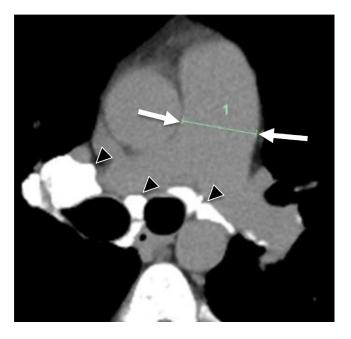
Axial noncontrast CT reveals an enlarged main pulmonary artery measuring 3.4 cm (straight white arrows). Marked calcified mediastinal and hilar lymph nodes are present (black arrowheads).
